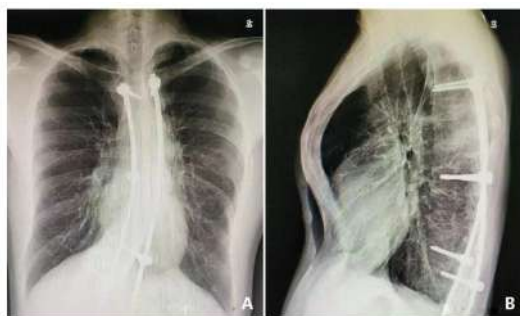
X-ray examination pictures. A, Positive view; B, Side view
